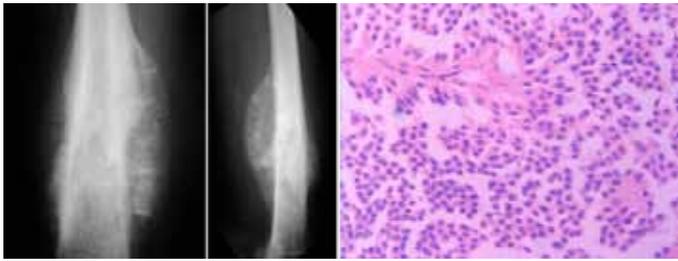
Ewing's sarcoma: x-rays (left) show onion-skin appearance (right).
